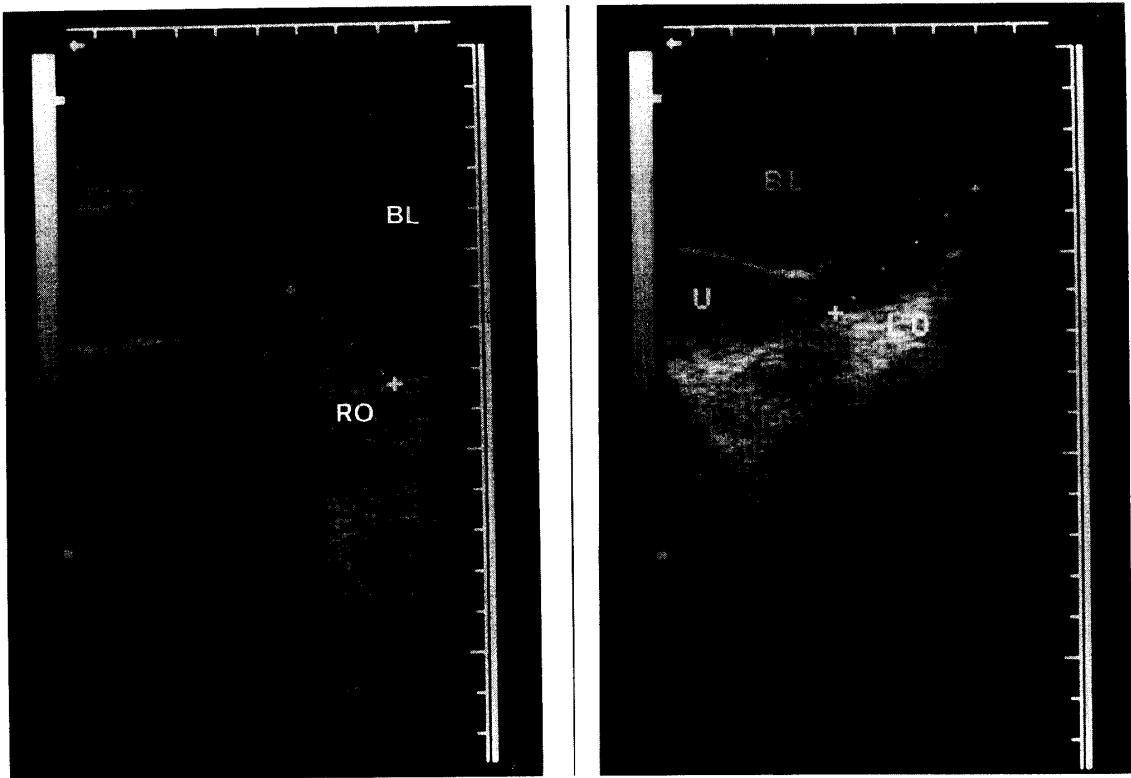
Ultrasonograms of bilateral peripheral cystic ovaries in Case 2. BL; bladder, LO; left ovary, RO; right ovary, U; uterus.
